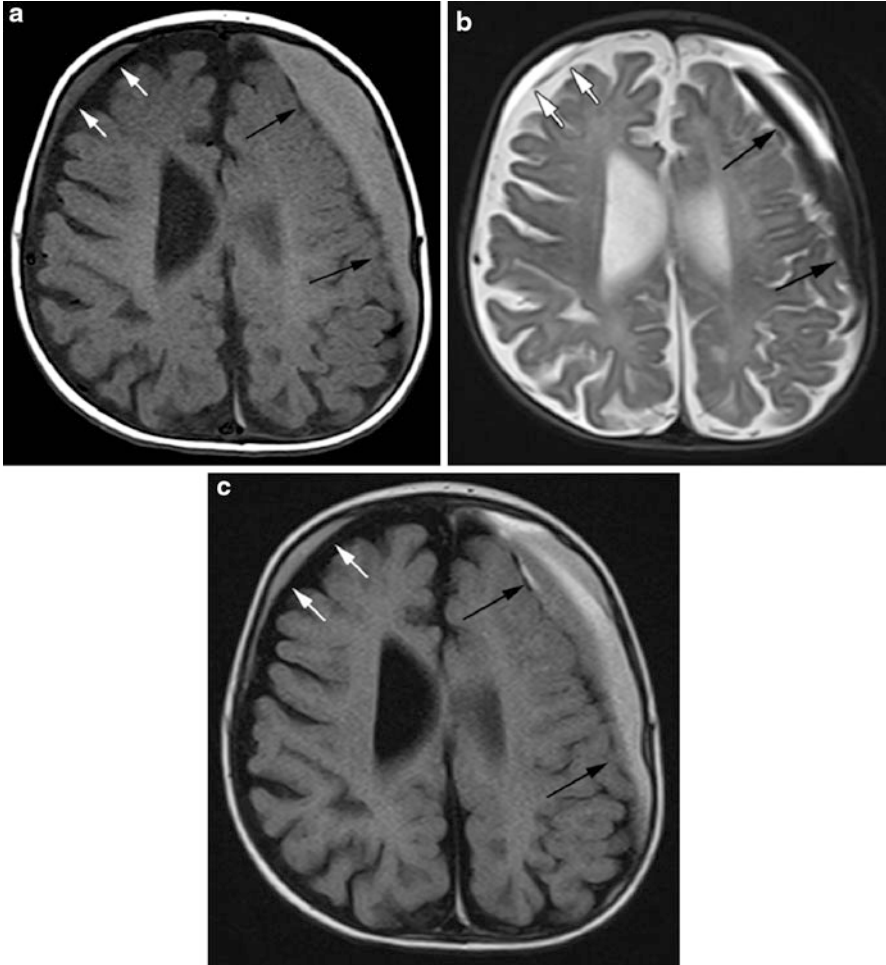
Subacute SDH. 12-month-old with unexplained intracranial hemorrhage, healing posterior rib fractures, and metaphyseal fractures of the distal femurs. Axial T1-weighted (a), T2-weighted (b), and FLAIR (c) images demonstrate a thin SDH along the right frontal lobe (*white arrows*). The collection is homogeneously hyperintense to CSF on all of the sequences consistent with late subacute blood products. A larger SDH along the left cerebral hemisphere (*black arrows*) is homogeneously hyperintense on the T1-weighted image consistent with the presence of methemoglobin. The collection is more heterogeneous on the T2-weighted and FLAIR images with blood products of various ages from a more recent hemorrhage
